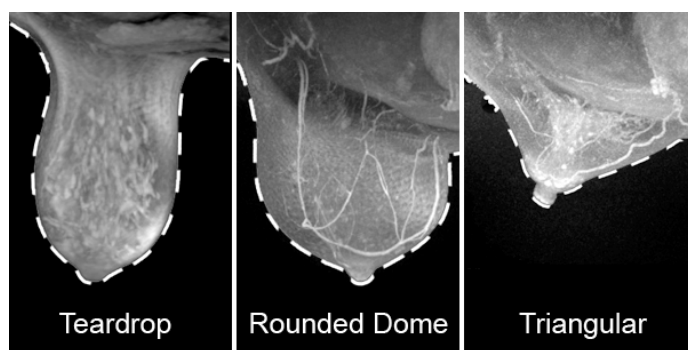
Sample Breast MRI images and shape classifications
